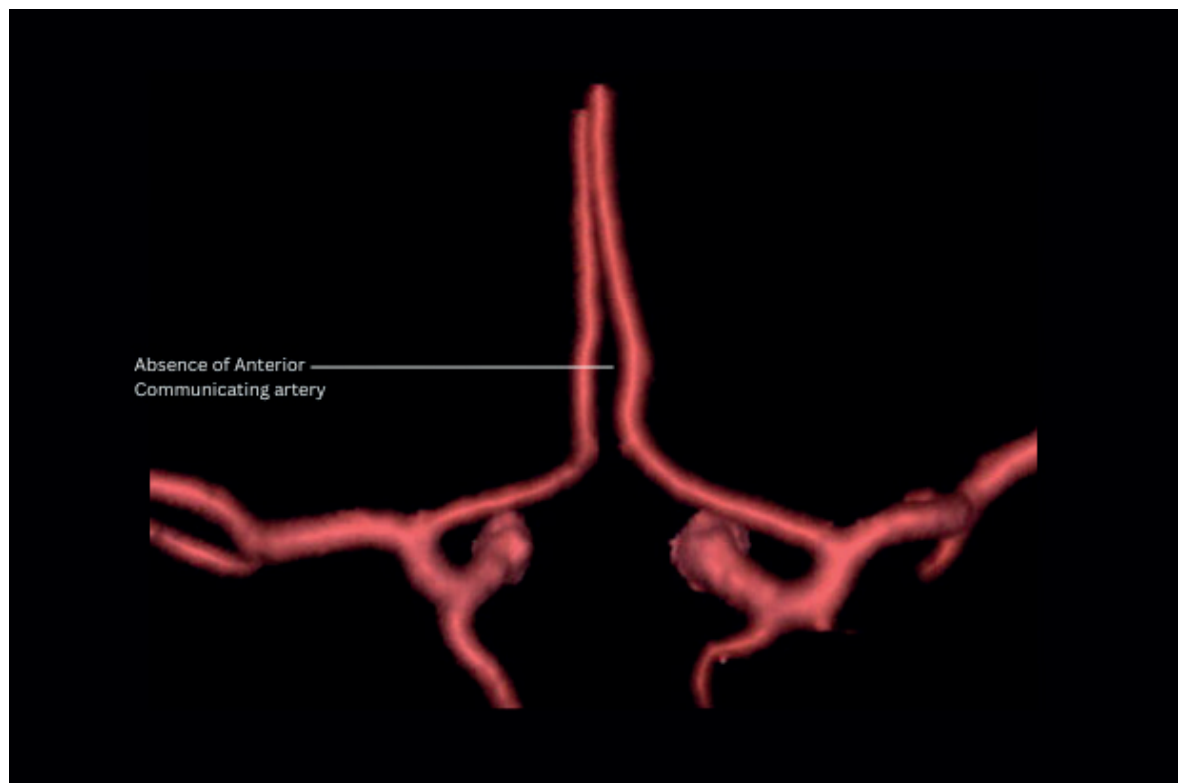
Volume Rendering CTA showing absence of ACoA of the circle of Willis in subjects with stroke.
